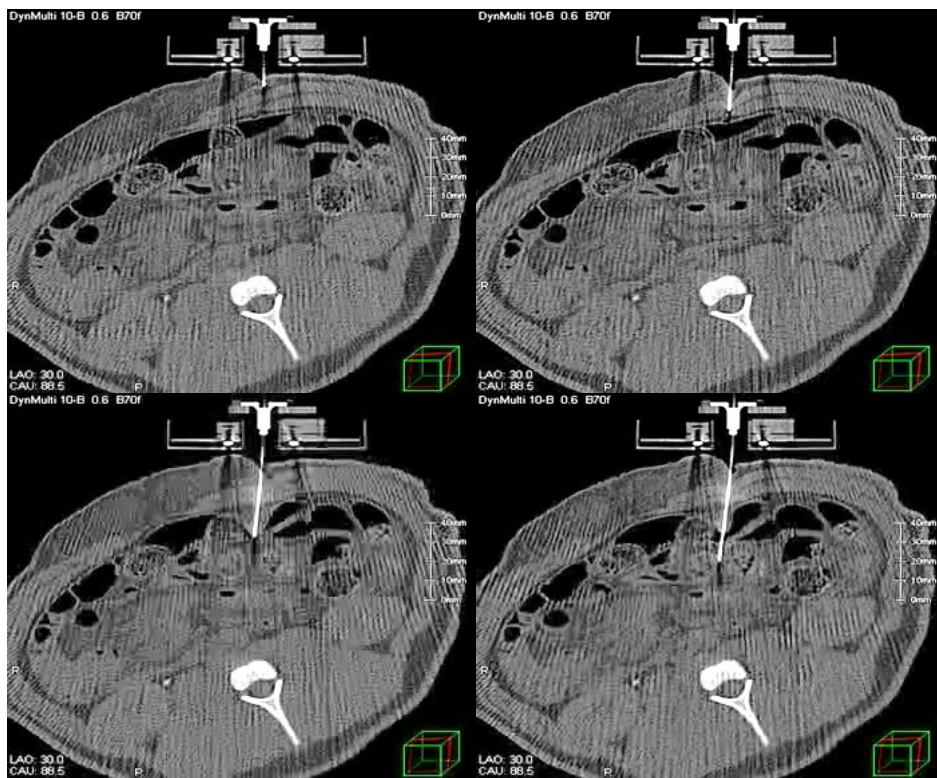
The sequential transversal CT images tracking the needle in No. 10 insertion path
